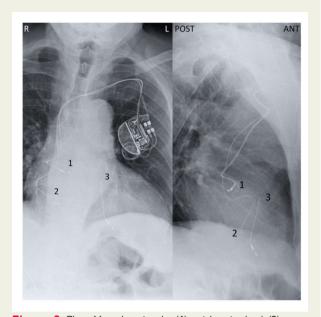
Chest X-ray locating the (1) atrial pacing lead, (2) proximal part of the ventricular lead, and (3) distal part of the ventricular lead. Dissociation of Parts 2 and 3 establishes lead rupture. *Left panel:* frontal view. *Right panel:* lateral view. (1) Atrial pacing lead. (2) Proximal part of the ventricular pacing lead. (3) Distal part of the ventricular pacing lead. ANT, anterior; L, left; R, right; POST, posterior. requisite first-line therapy for patients with CIED-related infections, and should be referred to specialized centres.
